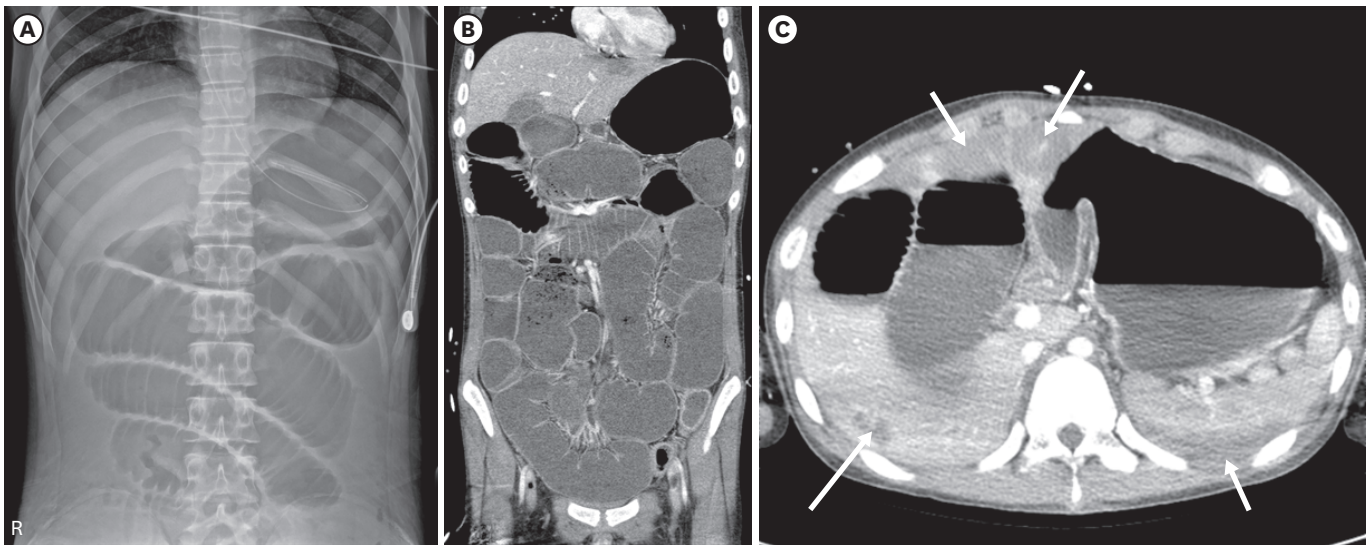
(A) Supine abdominal radiography shows diffuse gaseous-dilated small bowel loops in the central abdomen. Coronal (B) and axial (C) abdominal computed tomography scans show diffuse gas- and fluid-filled dilatation of entire hollow viscus, suggesting severe paralytic ileus, and multifocal hypoenhancing areas (arrows in C) in the liver and spleen, possible ischemic change due to mass effects.
